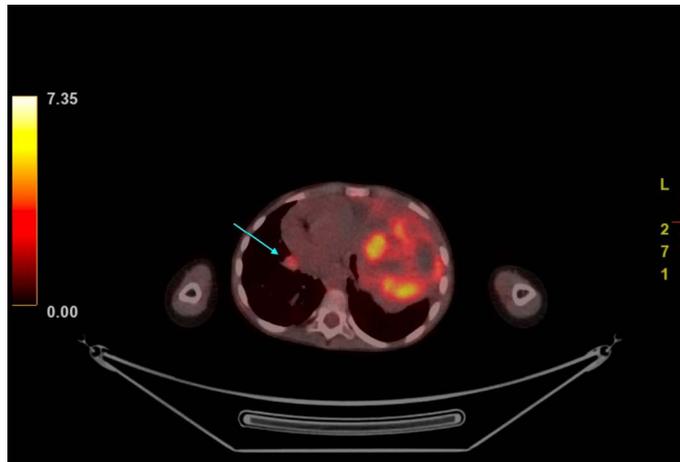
PET/CT are most sensitive for detecting lung and other distant or nodal metastases
